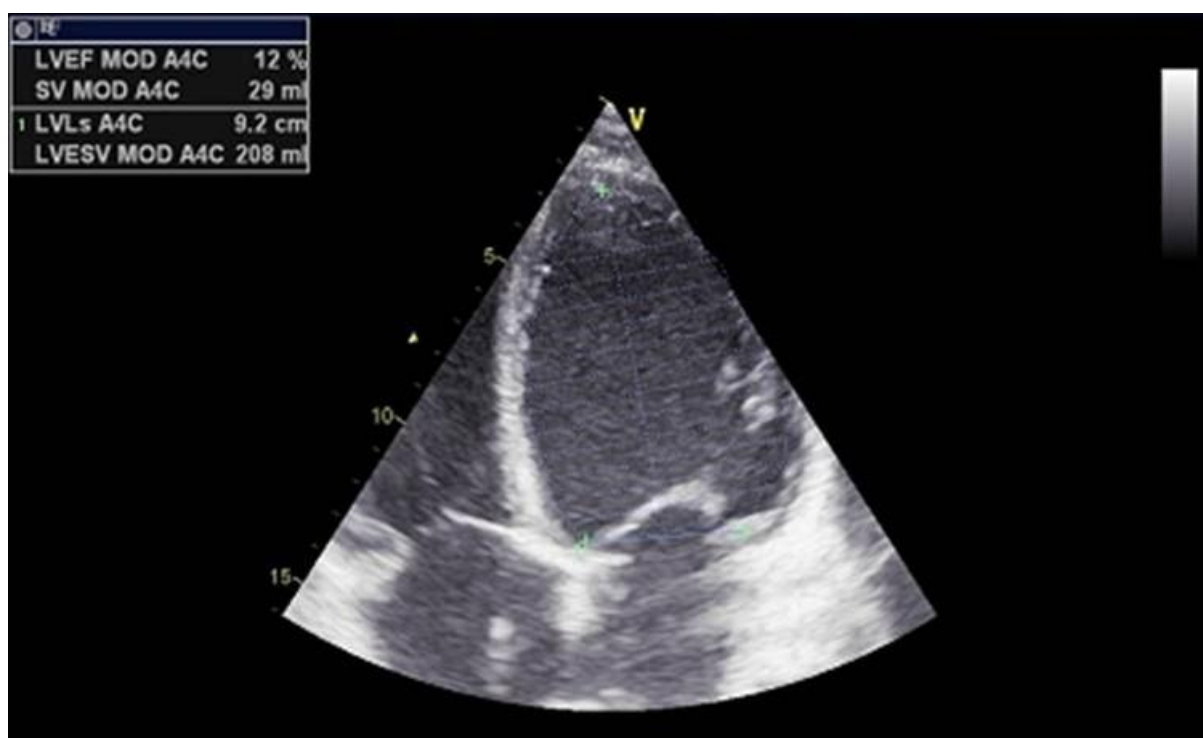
Transthoracic echocardiography showing severely impaired left ventricular contractility with a left ventricular ejection fraction (LVEF) of 12%, [AS8] [MS9] as well as a significantly enlarged left ventricle with a left ventricular end-diastolic volume (LVEDV) of 208 ml. Right ventricle is smaller, with dimensions relatively within normal limits compared to the enlarged left ventricle.
